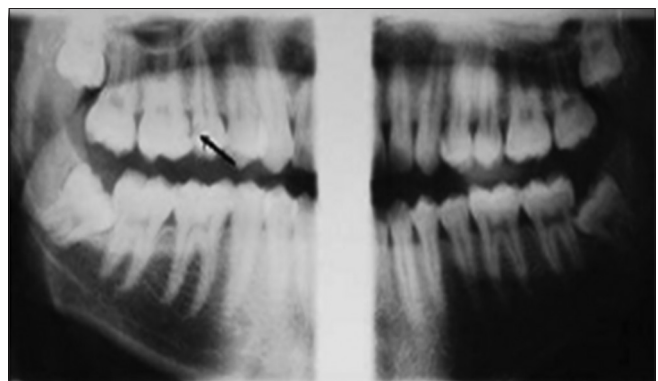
Panoramic radiograph in bitewing program
